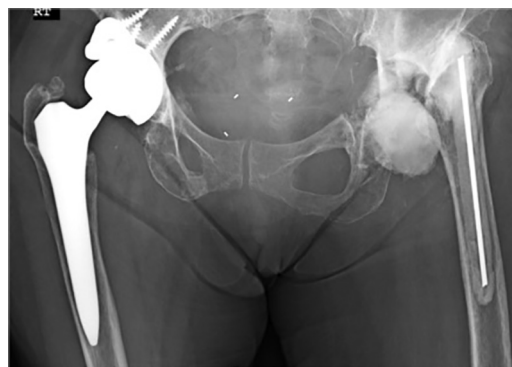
AP pelvic radiograph status post Right hip Acetabular component revision for aseptic loosening. Note the superior trabecular metal augment fixed with screws for a Paprosky Type IIB acetabular defect.
